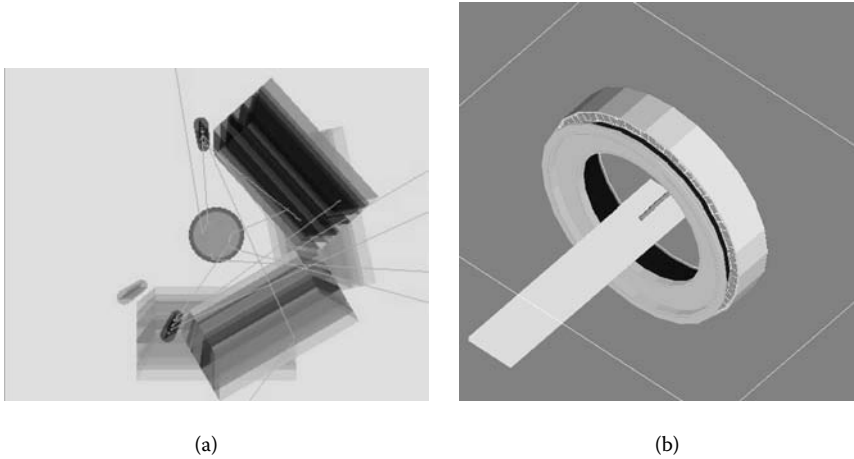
Example scanner types modeled in GATE: (a) SPECT system (IRIX-Beacon), and (b) PET system (ECAT HR+).
